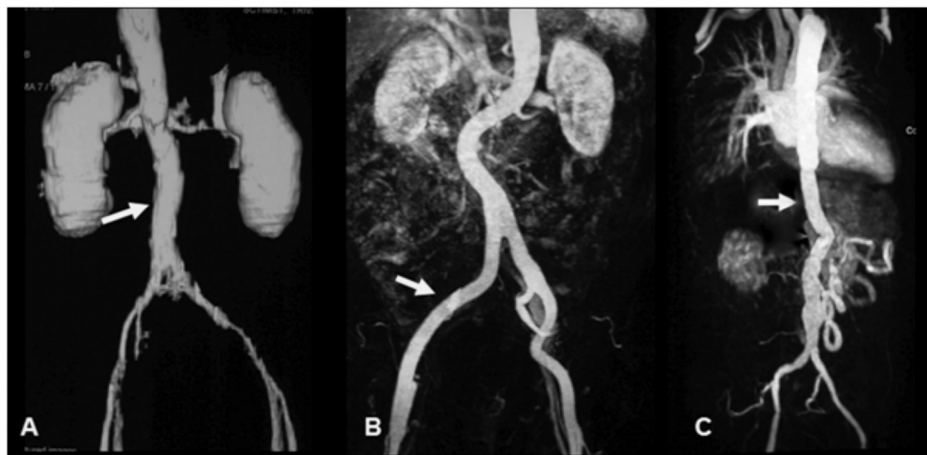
Follow up CT/MR angiograms of patients in the multicentric trials who underwent vascular reconstruction using test graft (white arrows), showing good results following open repair of abdominal aortic aneurysm at 5 years (A), aorto-femoral bypass for iliac occlusion at 4 years (B), and open repair of thoraco-abdominal aortic aneurysm at 6 years (C).
